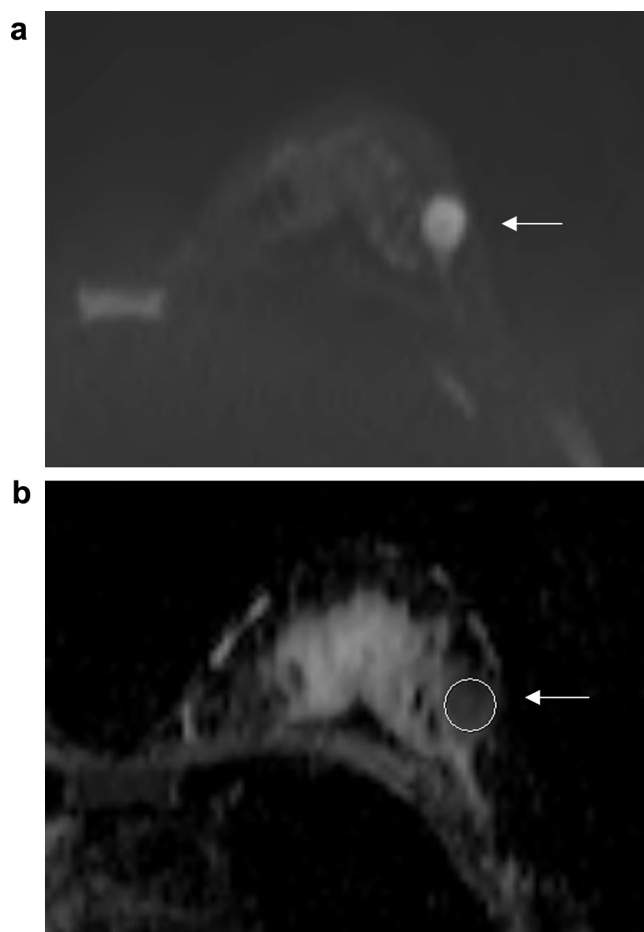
Invasive ductal carcinoma of the left breast in a 55-year-old woman. a: Axial diffusion-weighted MR image (b value of 1000 s/mm^2) shows high signal intensity mass (arrow). b: ADC map shows the mass with low signal intensity (arrow). The largest tumor cross section of the tumor was chosen, and the largest oval or round ROI was placed inside the tumor. The mean ADC value within the tumor was $0.816 \times 10^{-3} \text{ mm}^2/\text{s}$. Axillary node metastasis was found in two out of 13 resected nodes.
